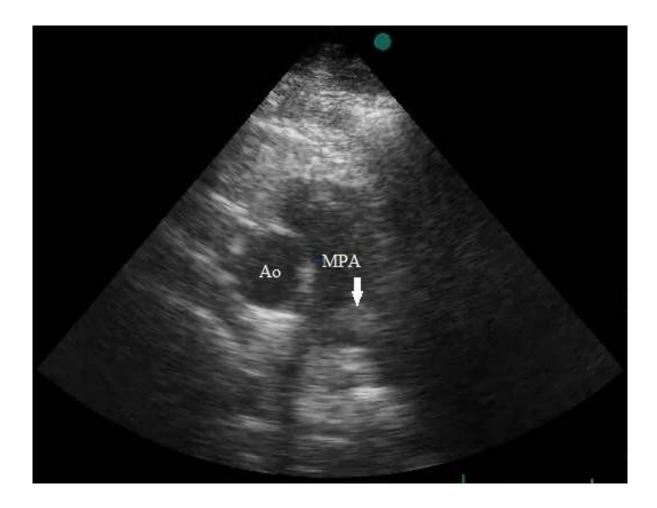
Parasternal short axis echocardiographic view: Arrow indicates a free-flouting thrombus at the pulmonary artery bifurcation. MPA: Main Pulmonary Artery; Ao: Aorta.
